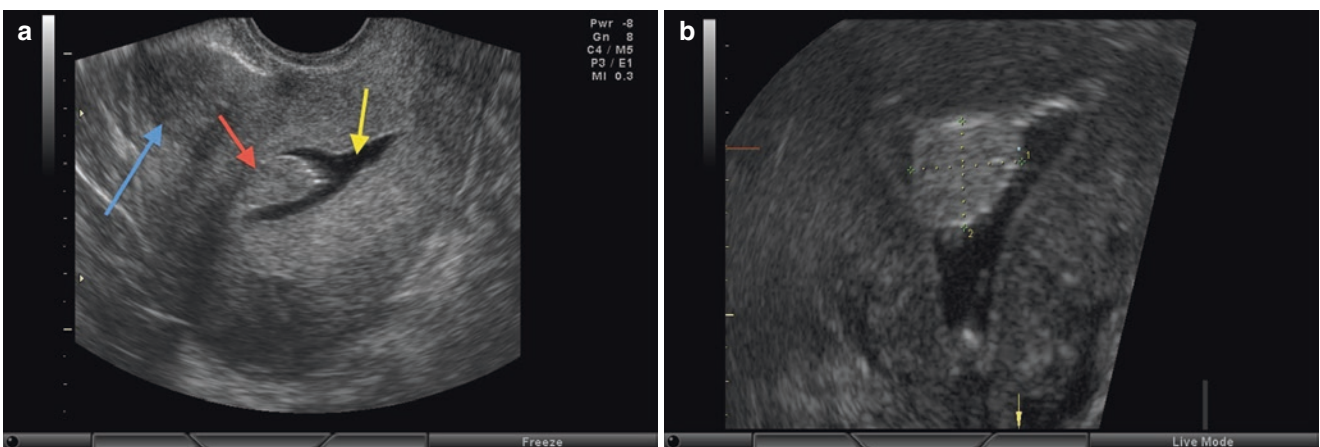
(a) Hysterosonography: Longitudinal ultrasound section of the uterus. The *blue arrow* shows a previous subserosal myoma. The *yellow arrow* shows anechoic fluid in the endometrial cavity (saline infused) that works as a contrast, allowing better identification
